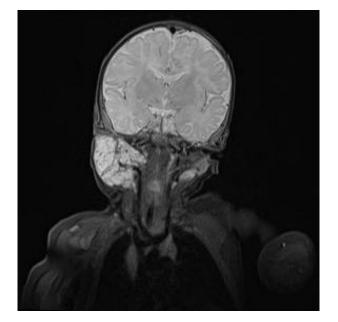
Coronal magnetic resonance imaging scan of case three, prior to treatment, showing diffuse right parotid enlargement.
